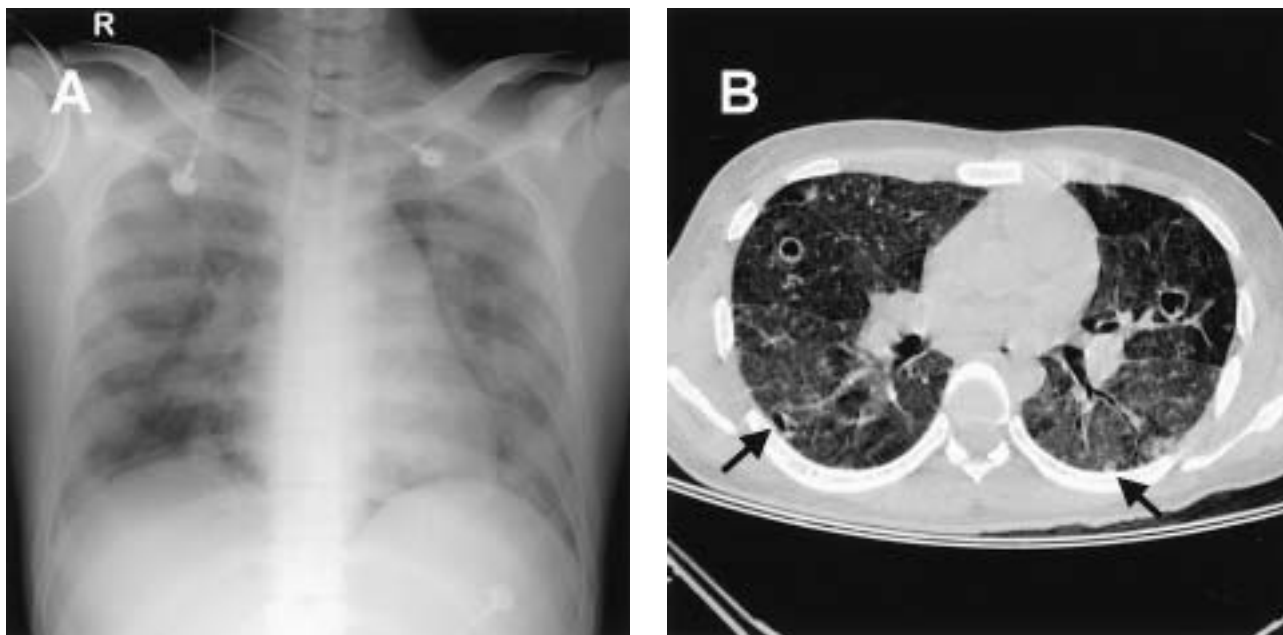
Image studies on the day of admission. (A) Chest radiograph shows bilateral nodular infiltrations. (B) CT scan reveals multiple thin-walled cavities. Some of them are located subpleurally (arrows).
